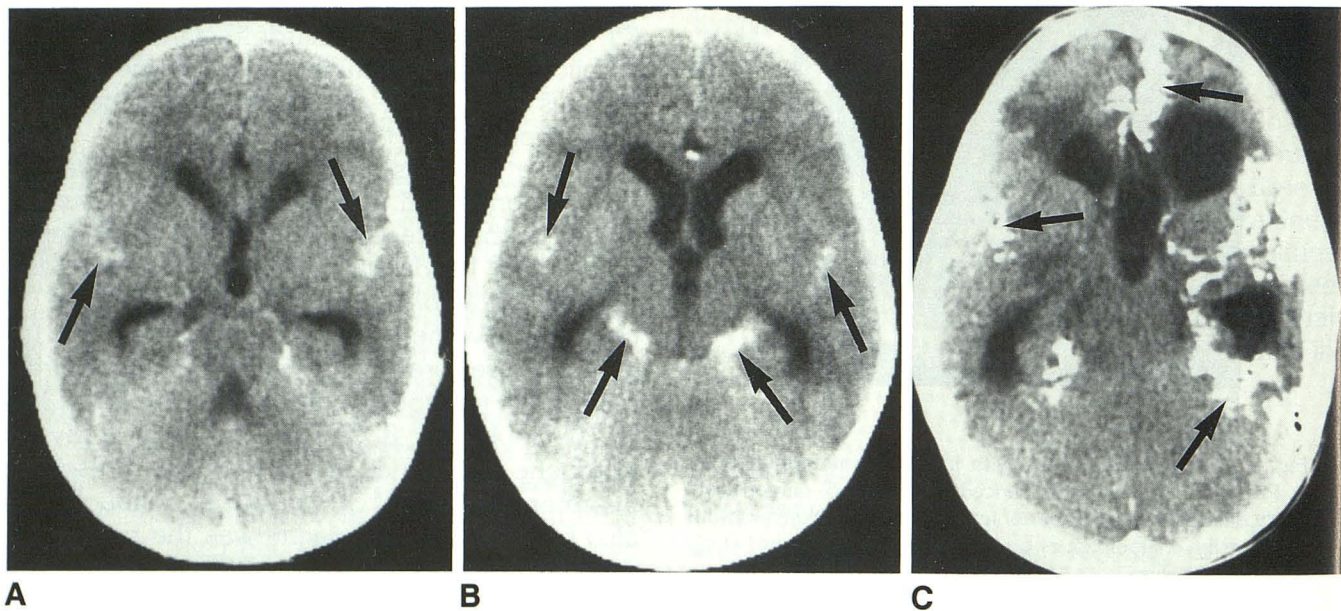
Two-year-old boy with primary oligodendrogliomatosis and hydrocephalus. Contrast-enhanced CT (A and B) shows abnormal enhancement of the cisterns and fissures (*black arrows*) plus hydrocephalus. Follow-up axial nonenhanced CT study (C) 1 year after ventricular shunting, biopsy, and radiotherapy, shows extensive leptomeningeal calcification (*black arrows*).
